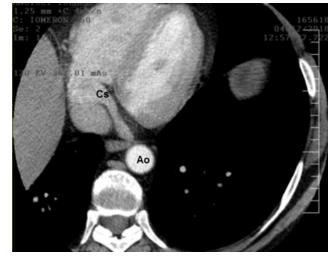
Computed tomography of the heart. The coronary sinus drains in the right atrium. Cs=coronary sinus; Ao=aorta.
